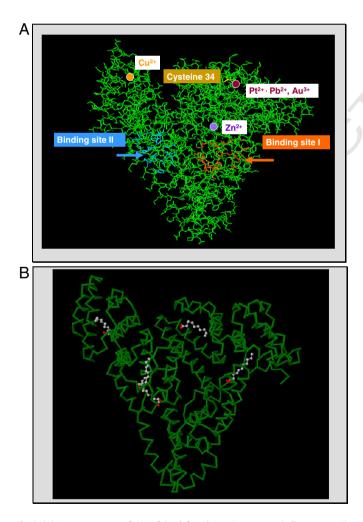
(A) X-ray structures of HSA of the defatted protein structure (pdb-entry 1ao6); (B) the albumin structure in which five molecules of myristic acid are bound (pdb-entry 1bj5). The binding sites for metal ions, fatty acids as well as the binding sites I and II (the so-called Sudlow's binding sites) where numerous drugs are physically bound are highlighted.
